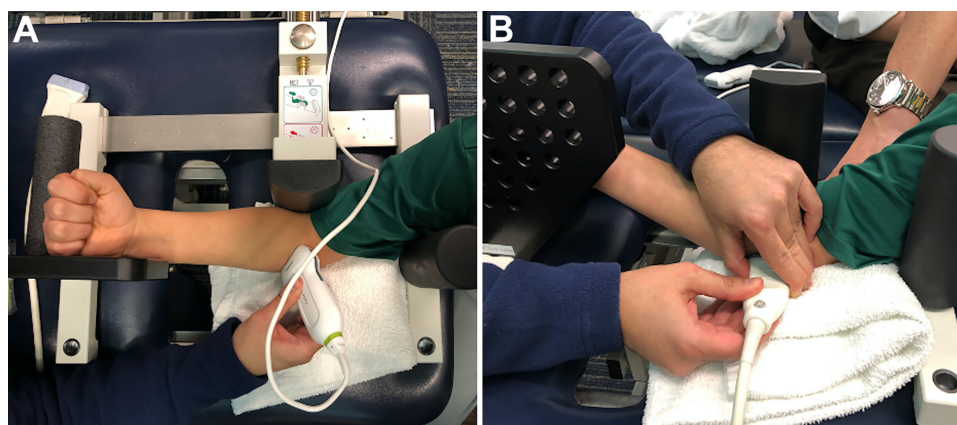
(A) Top view of position of forearm and location of ultrasound probe to identify flexor-pronator mass for glycogen storage evaluation. (B) Setup of standardized stress device and location of ultrasound transducer to measure medial ulnohumeral joint distance.
